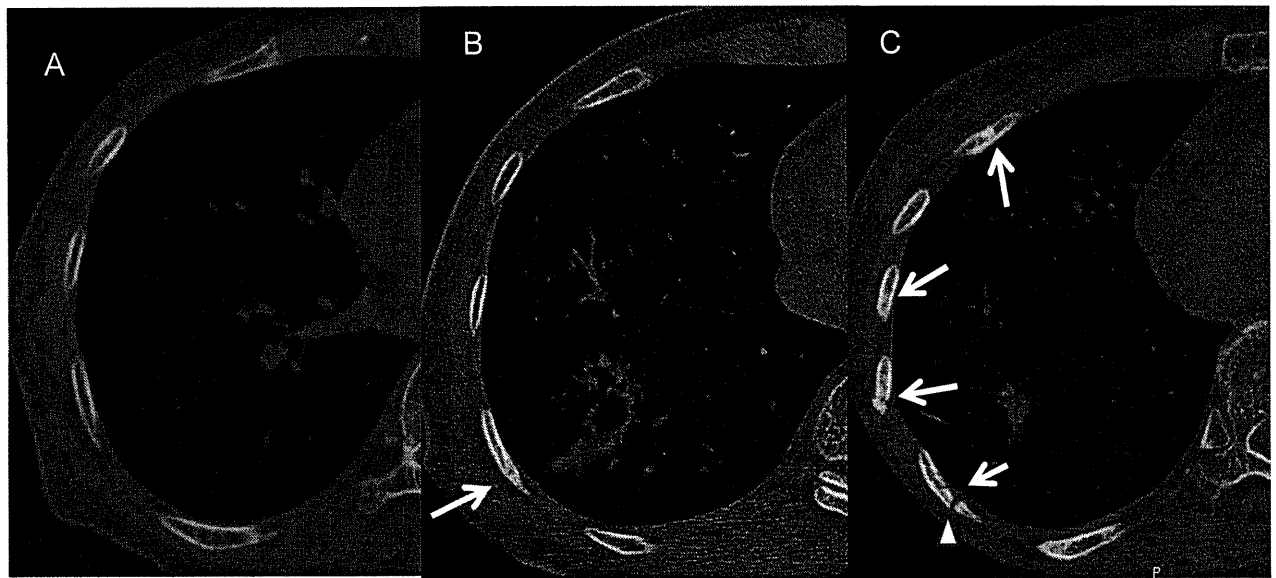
A 85-year-old woman with adenocarcinoma. A, Preradiotherapeutic thin-section CT at the bone window shows no marked abnormality of the ribs. B, At 18 months after SRT, bone sclerosis of the rib adjacent to the lung tumor appeared (arrow). C, At 30 months after completion of SRT, multiple rib fractures with areas of sclerosis are seen. Pseudoarthrosis is present in one of the fractured bones (arrow head).
